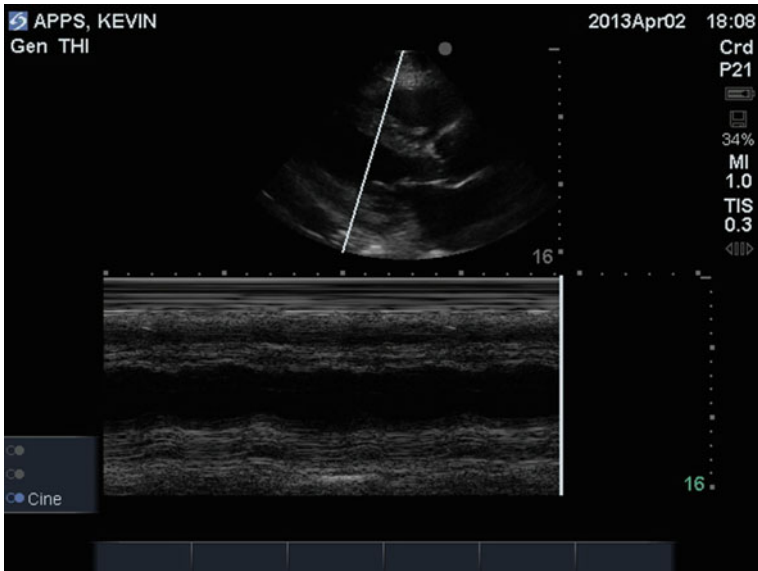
M-mode, showing the change over time across a single plane of Ultrasound
